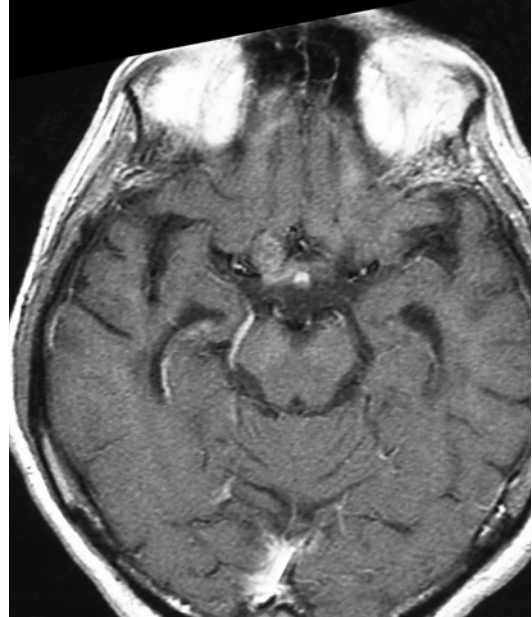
CT scan revealing subacute hemorrhage of the left optochiasmatic cavernoma
